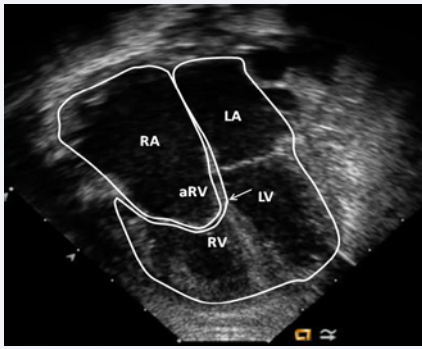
An apical four-chamber view showing all chambers of the heart in end diastole. A tracing on the image shows the two areas used to obtain the ratio (Celermajer index) for prediction of outcome in fetal and neonatal echocardiograms (see text for further details). The abbreviations are the same as those used in Figure 5. Reproduced from Reference [12].
